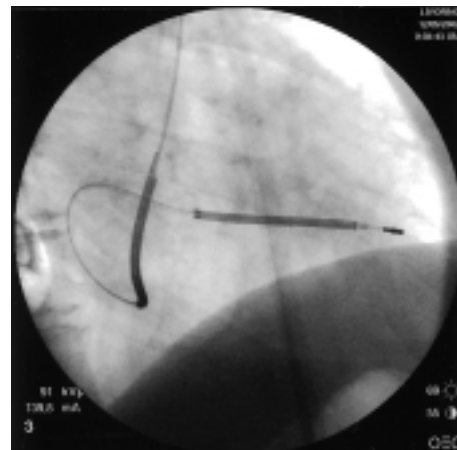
Right anterior oblique radiographs of the chest. The right oblique view shows the proximal lead coil at the confluence of the left superior vena cava with the coronary sinus.
